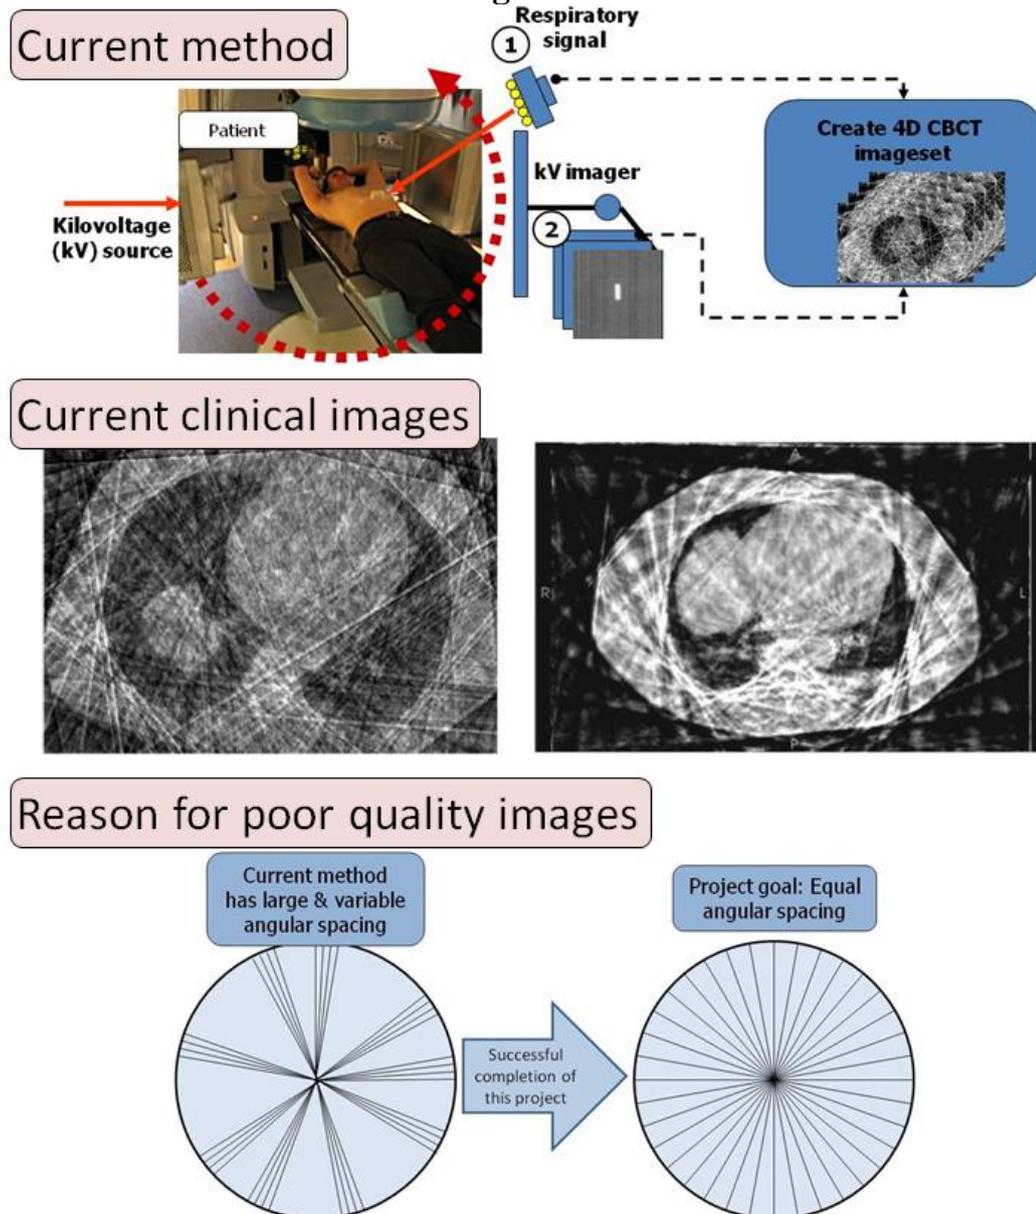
Top: in the current 4D CBCT method there is no feedback of the respiratory signal to the imaging system. Middle: this limitation causes streak artefacts in clinical images. Bottom: the reason for poor quality clinical images^{10, 11} is large angular spacing between projections with fixed rotation speed (left). The solution is to obtain equispaced projections by the proposed RM 4D CBCT (right).
